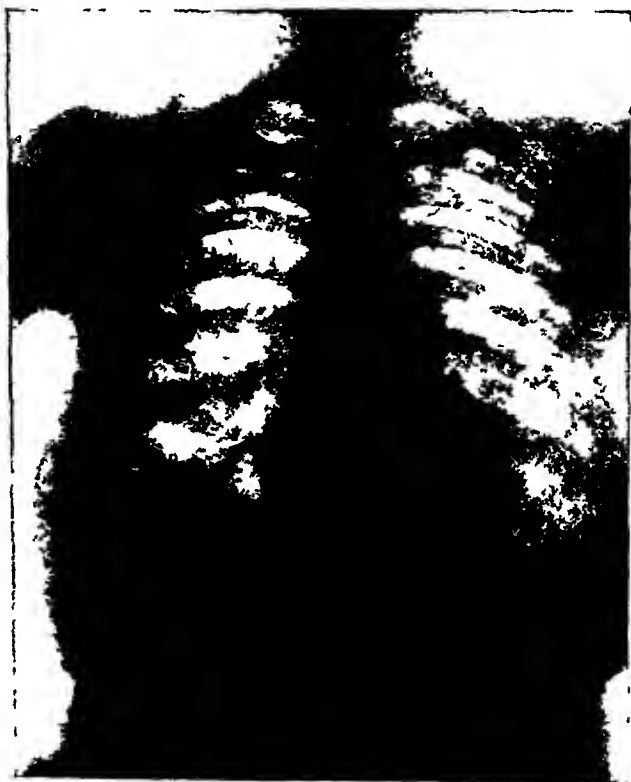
Case III. x-Ray taken April 27, 1925. There is no evidence of the previous lesion.
